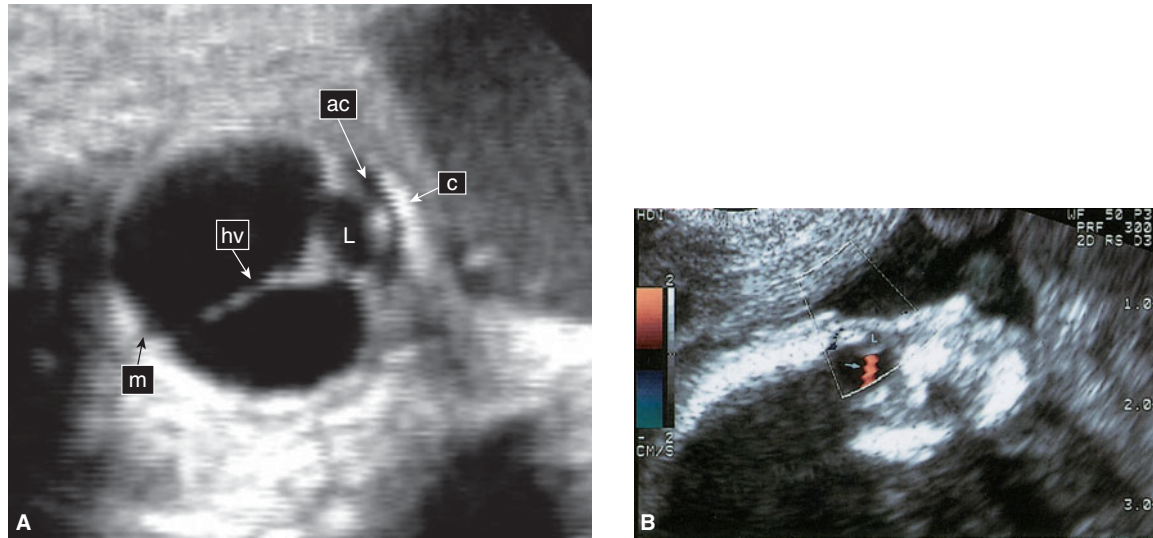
The normal fetal eye (A) Normal fetal eye at 27 weeks, visualized by transvaginal sonography (TVS). ac, anterior chamber; c, cornea; hv, hyaloid vessels; L, lens; m, macula. (B) Color-flow imaging reveals the active arterial flow in the hyaloid artery (arrow) toward the lens (L).
